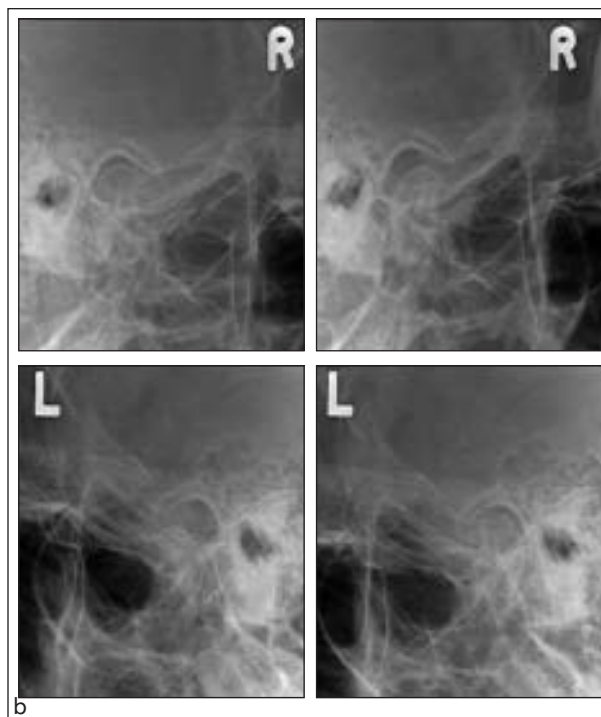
Plain radiographs of the TMJs. (a) Orthopantomogram showing degenerative change of both TMJ condyles. (b) Transcranial view of the TMJ showing marked restriction of condylar movement with the condyles remaining inside the mandibular fossa during maximum mouth opening.
